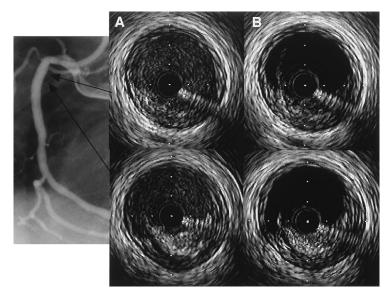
A case of an intimal flap that occurred at the proximal edge of the Palmaz-Schatz stent after high-pressure inflation. Coronary angiography showed a good result without dissections. *A*, a plain intravascular ultrasound image of the proximal edge of the Palmaz-Schatz stent is shown; *B*, a negative contrast image clearly revealed an intimal flap that may be a cause of an adverse event. This flap was successfully covered after additional Palmaz-Schats stent implantation.
